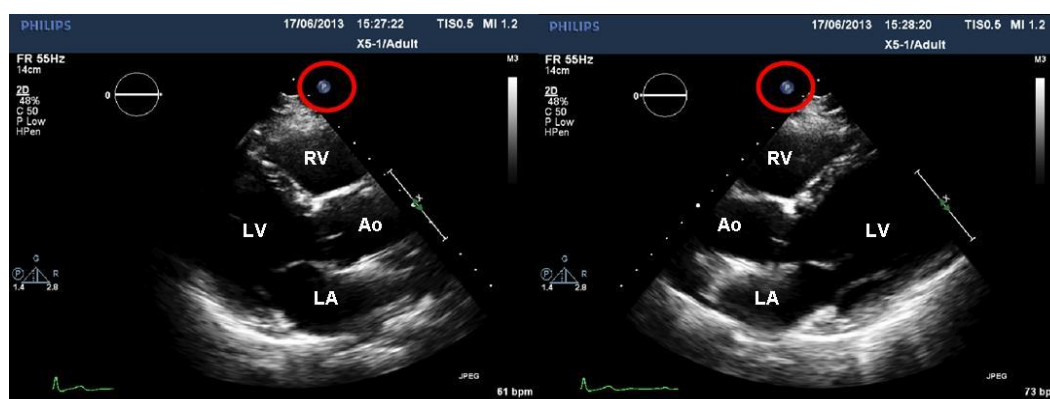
Parasternal long-axis view showing the effect of reversing the screen orientation marker. In the image to the left, the machine is preset for cardiac scanning, and the screen orientation marker is to the right of the ultrasound sector display (circled in red). In the image on the right, the machine is incorrectly set up, with the orientation marker (circled in red) shown to the left of the ultrasound sector display.
